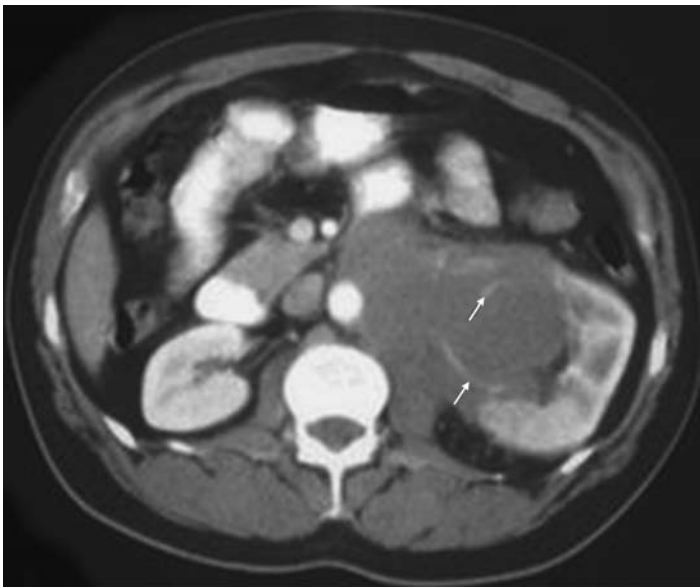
Contrast-enhanced CT showing a large left lymphomatous retroperitoneal mass invading the renal hilum, renal parenchyma, and the left psoas muscle. Characteristically the renal vessels are distorted but not invaded and demonstrate contrast enhancement (arrows).
